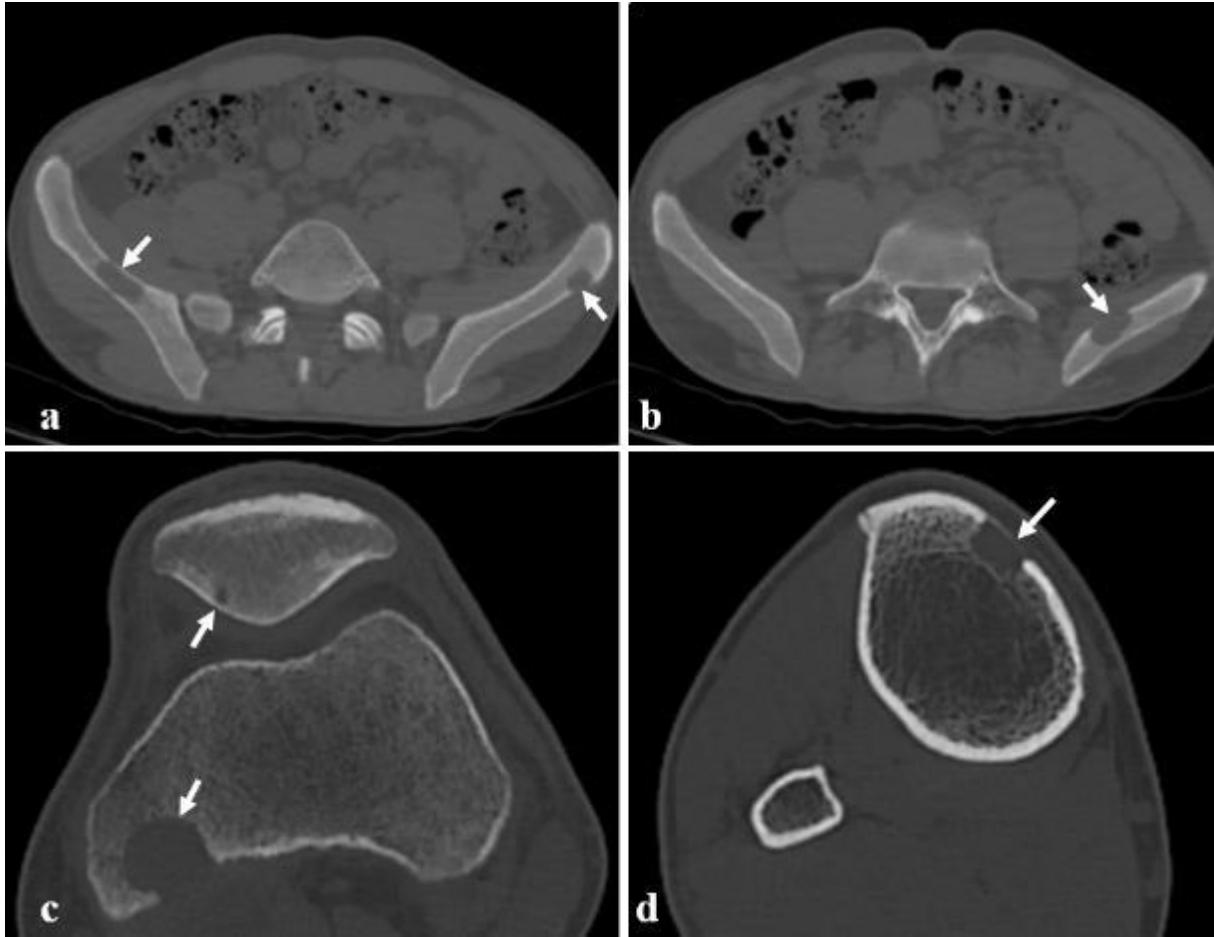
Axial CT slices show well-margined osteolytic lesions of the pelvic bones, responsible for the rupture of the cortex of the left iliac bone. c. and d. : Juxtacortical osteolytic lesions of the left femoral condyle and patella (c) and right tibia (d), with a discontinuity of the femoral cortex and thinning the tibial cortex
